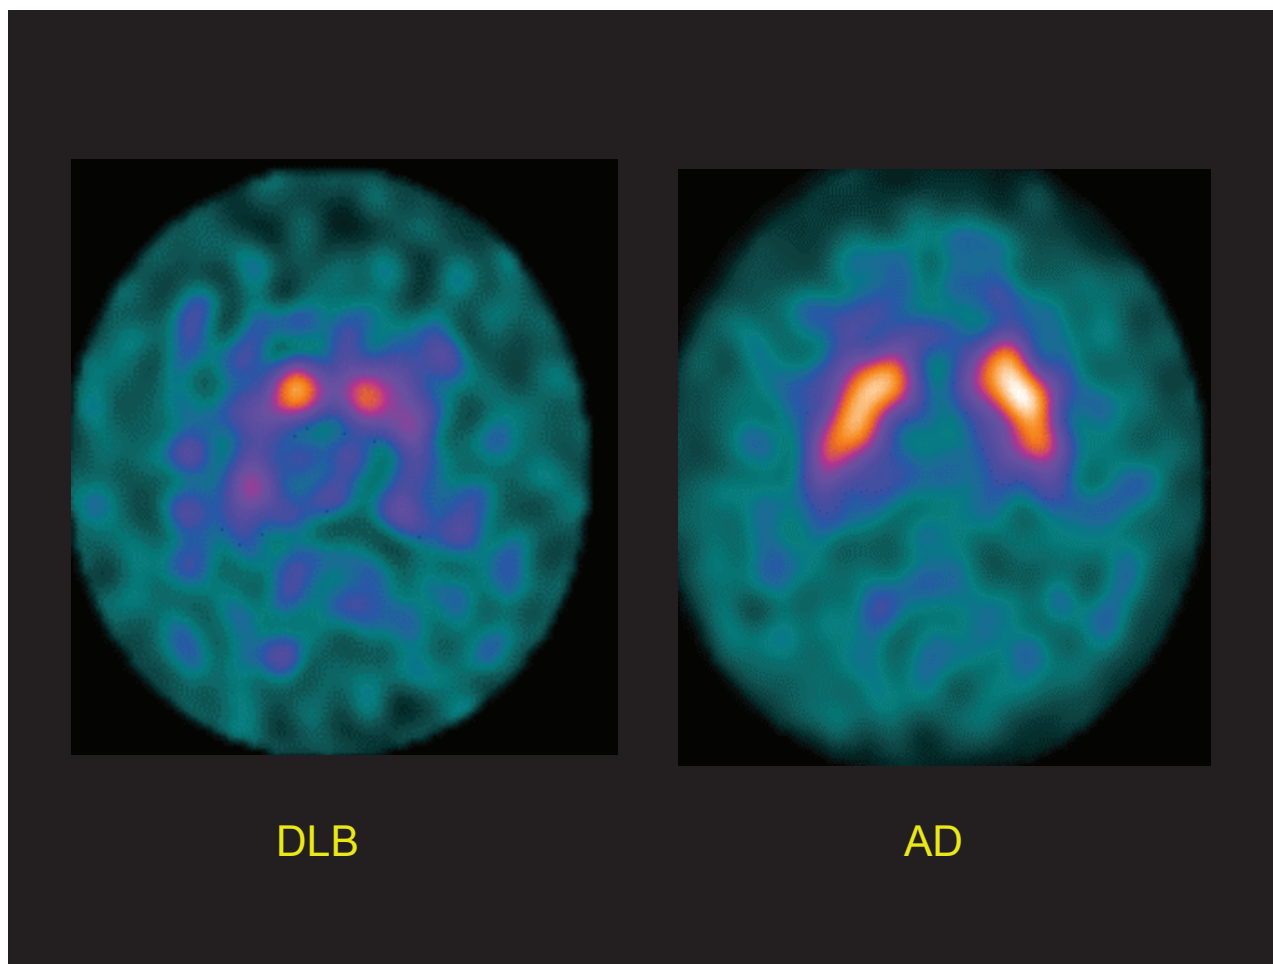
The images depict striatal dopamine transporter binding of with ^{123}I -ioflupane – SPECT in one patient with dementia with Lewy bodies (DLB) (right panel) and in one with Alzheimer's disease (AD) (left panel). It can be appreciated that ^{123}I -ioflupane uptake in the basal ganglia is normal in AD but markedly reduced in the DLB patient, consistent with significant impairment of striatal dopamine nerve terminals.
